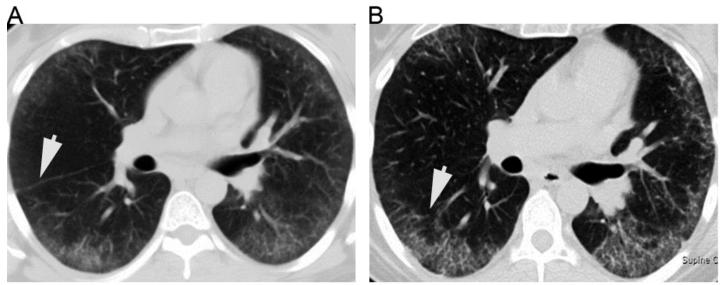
CT image of nonspecific interstitial pneumonia (NSIP) in our patient with dermatomyositis. A. In early, cellular NSIP, diffuse bilateral ground glass opacities (GGO) are indicators of ongoing lung inflammation. The arrow points at clear demarcation between normal and diseased lung (straight edge sign). B. CT scan two years later with fibrotic NSIP and resolution of GGO. The arrow points at fibrosing lung tissue.
